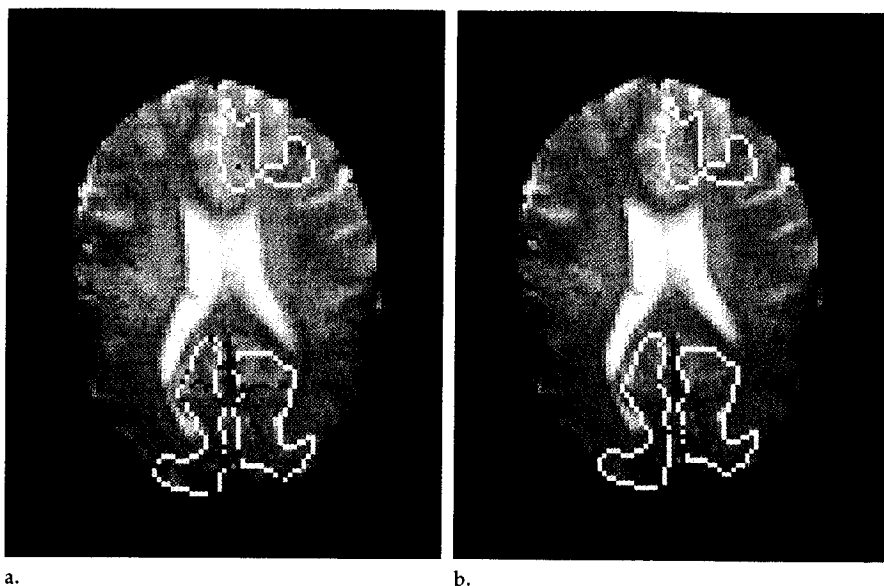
Subject 4. GRE MR images obtained with the (a) dynamic and (b) BOLD techniques show activated pixels (in red) within the anatomic ROIs (in white).
